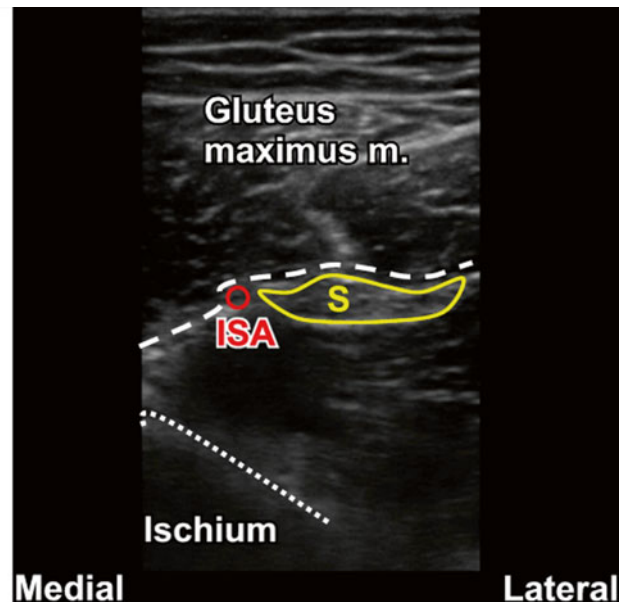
Ultrasound image of posterior gluteal sciatic nerve block location. *S* sciatic nerve, *IGA* inferior subgluteal artery
